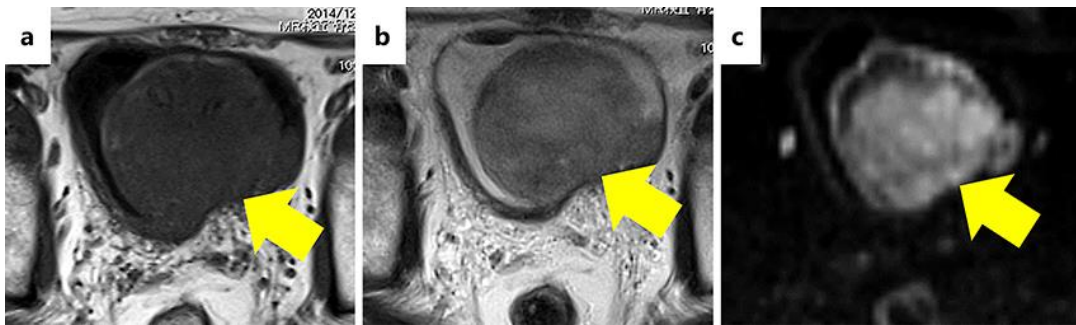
MR images. a T1-weighted image. b T2-weighted image. c Diffusion-weighted image. The arrows indicate the tumor.
